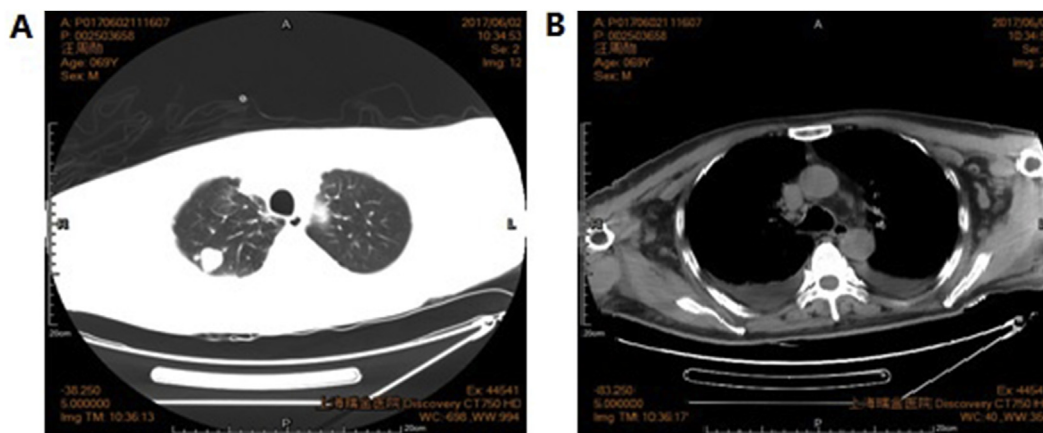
Pulmonary nodule (A) and mediastinal adenopathy (B) demonstrated in the thoracic CT scan during admission.
